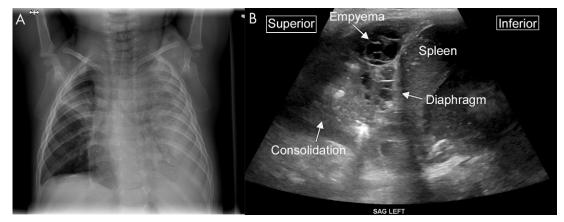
Complex collection on lung US. A, Anteroposterior chest radiograph demonstrates near complete opacification of the left hemithorax, with loculated pleural fluid tracking along the left lateral chest wall in an 8-month-old male infant. In addition, a focal consolidation is present in the right upper lobe. B, Sagittal US image from the same patient shows consolidation within the lung and a multiseptated complex pleural fluid collection consistent with empyema.
